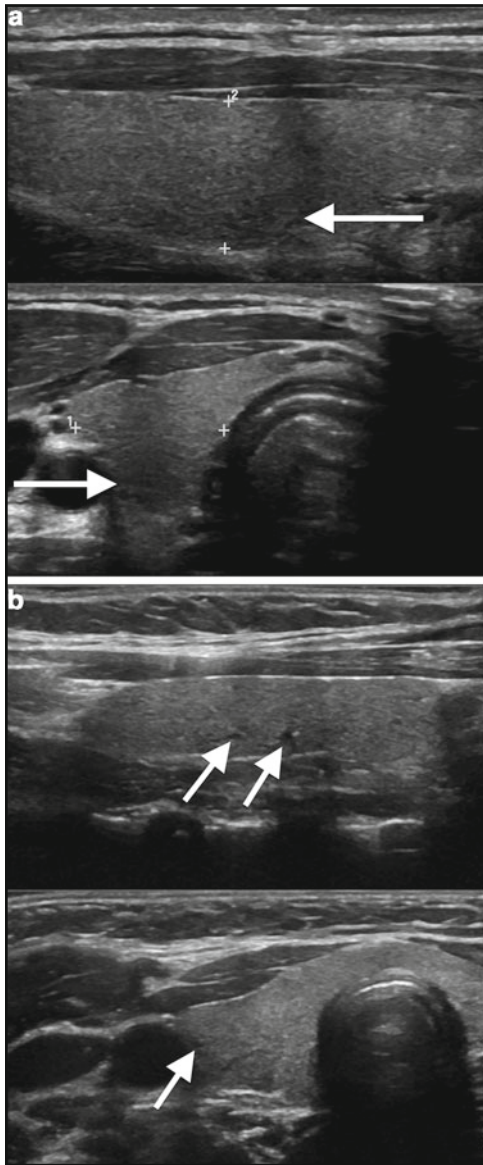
Ultrasound findings in five children with thyroiditis of increasing severity. (a) 17-year-old boy: There is subtle coarsening of the thyroid echotexture in the posterior portion of the gland (*arrows*). (b) 13-year-old boy: In addition to mild coarsening, there are a few oval hypoechoic foci (*arrows*) in the posterior portion of the gland. (c) 12-year-old boy: The posterior gland has become progressively more heterogeneous (*arrows*), losing the smooth echotexture that characterizes the normal thyroid. (d) 7-year-old girl: Numerous thin, echogenic septations (*arrowheads*) have become visible
